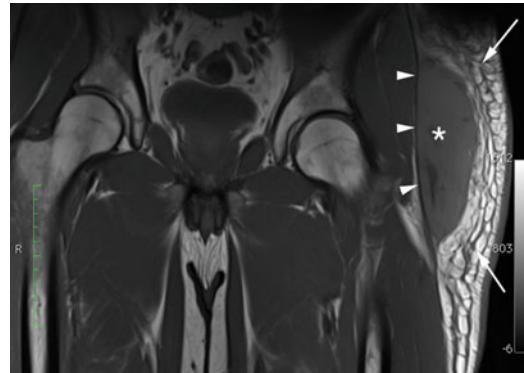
T1-weighted coronal image (TR 731 ms/TE 20 ms, slice thickness 6 mm) of a 47-year-old male patient after trauma (bicycle accident) showing a Type 1 ML lesion. The left thigh demonstrates an oval hypointense lesion (*asterisk*) which dissects the virtual space between the subcutaneous fatty tissue (*arrows*) and the iliotibial band (*arrowheads*)
